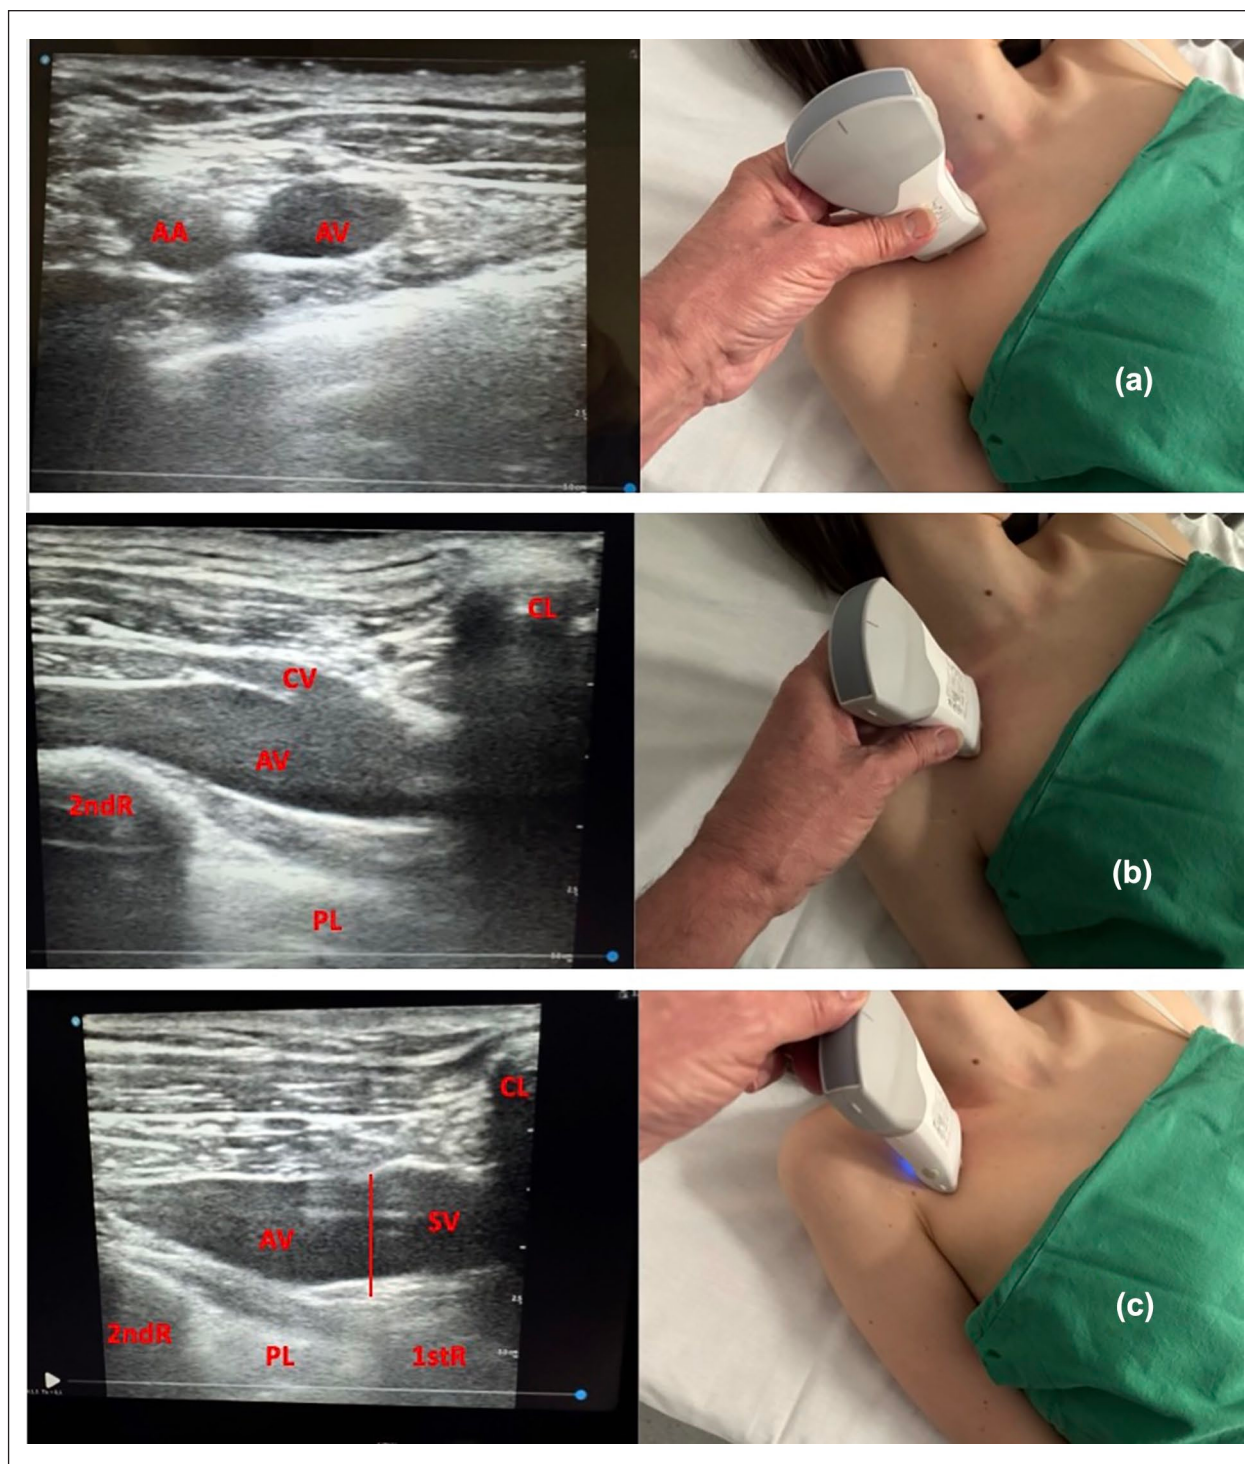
Ultrasound visualization of the axillary vein in the infraclavicular area, in short axis (a) and in long axis (b); the transition between axillary vein and subclavian vein can be visualized only in long axis, when the shoulder is in a forced elevated position (c). 1stR=first rib, 2ndR=second rib, AA=axillary artery, AV=axillary vein, CL=clavicle, CV=cephalic vein, PL=pleura, SV=subclavian vein.
